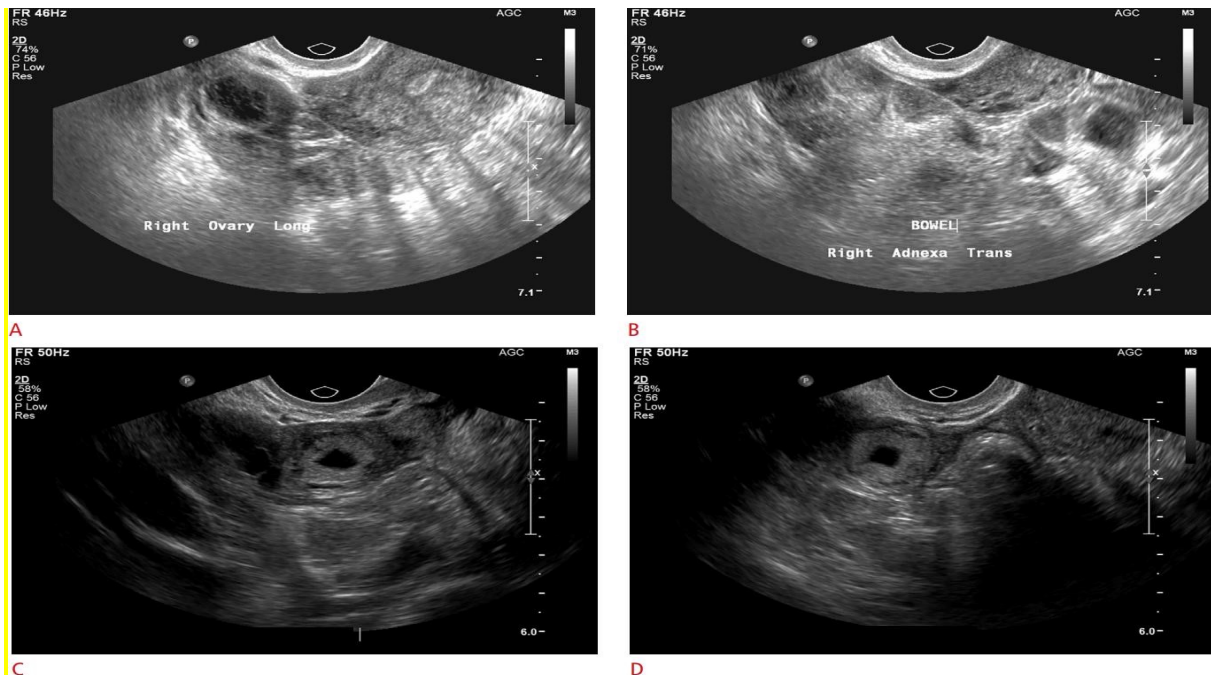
Transvaginal ultrasound images demonstrating ovarian morphology and adnexal findings. (A–D) Grayscale ultrasound views showing ovarian follicles, stromal echogenicity, and adnexal anatomy commonly evaluated in polycystic ovary syndrome (PCOS).
